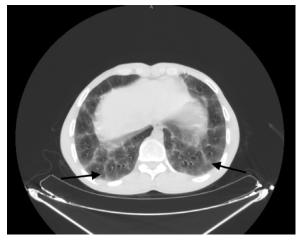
Noncontrast abdominal CT image evaluated in the lung window.
